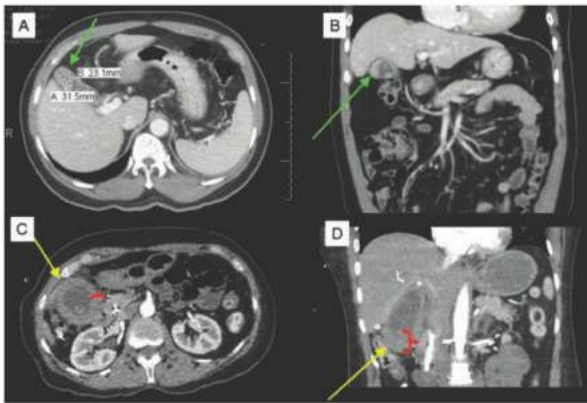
• Axial (A,C) and coronal (B,D) contrast-enhanced CT findings of gallbladder cancer. Typical appearance may include that of a mass with intraluminal extension (green arrows; panels A,B) or diffuse thickening of the gallbladder wall (yellow arrows noting region of gallbladder, and red brackets noting thickened area; panels C,D) with a measured wall thickness in excess of 2 mm.
